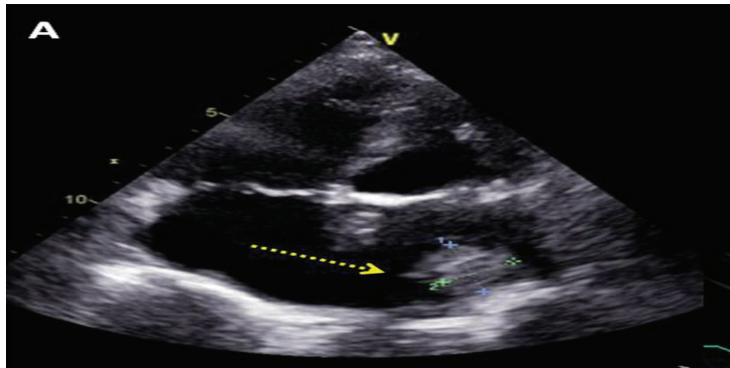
Transthoracic echocardiography (TTE) shows a mobile large echogenic mass (1.9x2.3 cm) in the posterior wall of the left atrium.
